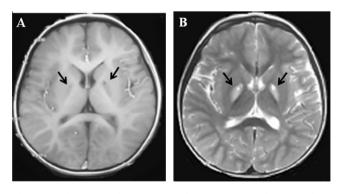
Brain magnetic resonance image (MRI) of the patient. Hypointense lesions on T1-weighted images (A) and hyperintense lesions on T2-weighted images (B) can be seen in the basal ganglia and thalamus.
